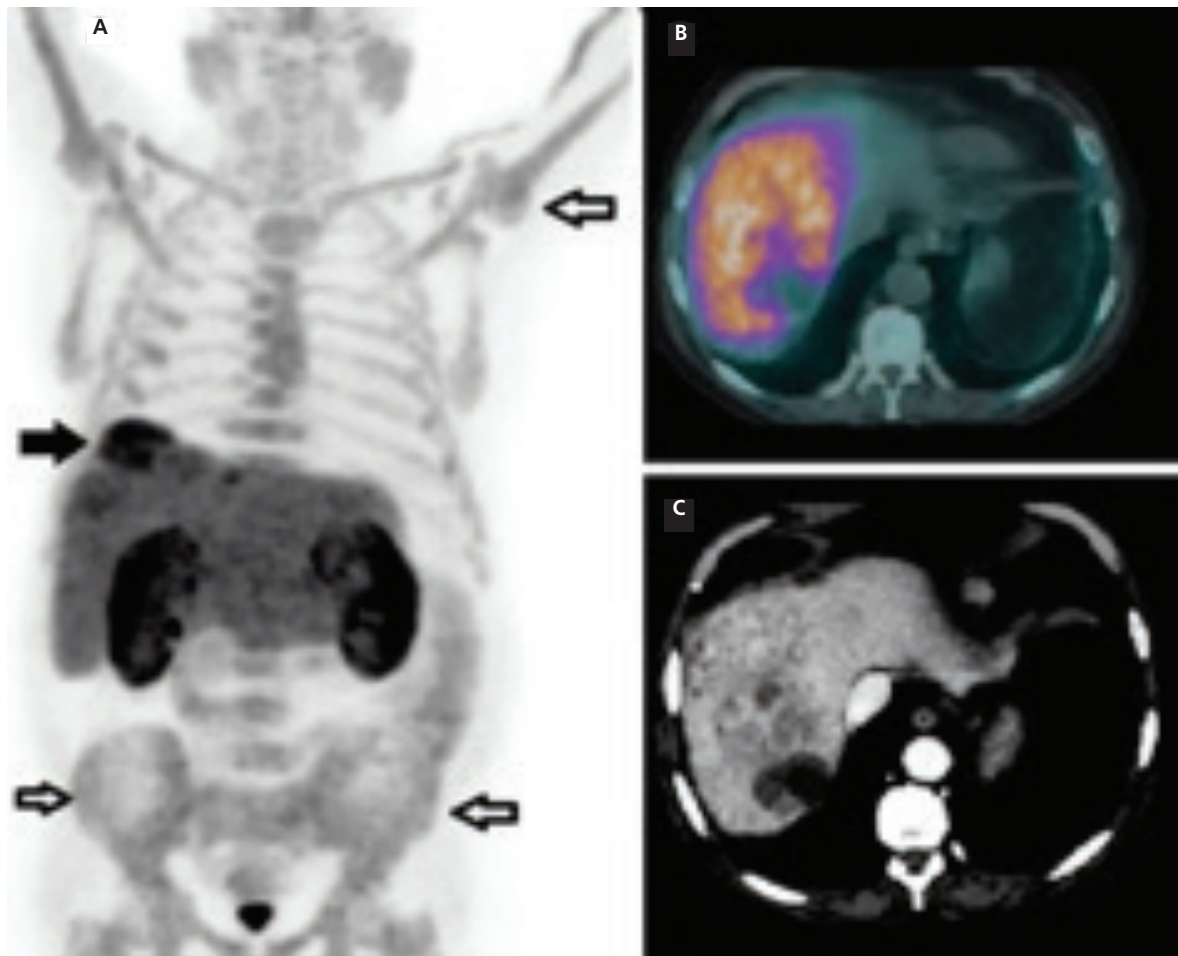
A 57-year-old man was diagnosed as having thalassemia intermedia at the age of 3 years (genotype CD39/IVS 1-6). He received sporadic blood transfusions since childhood and was submitted to splenectomy at the age of 15 years due to giant splenomegaly. Over the years, he developed hemochromatosis secondary to iron overload and was infected by hepatitis C, which was most probably transmitted via blood transfusion before 1990. In April 2018, during a periodical clinical follow-up, an abdominal ultrasound examination revealed multiple lesions in the right hepatic lobe, subsequently confirmed by contrast-enhanced/computed tomography (ce-CT). The patient underwent biopsy which resulted positive for well-differentiated hepatocellular carcinoma (HCC). He received sorafenib until September 2018 when treatment was discontinued due to the onset of cutaneous toxicity and evidence of progressive disease shown by ce-CT. He was enrolled for a loco-regional treatment of the hepatic lesion through radioembolization with ⁹⁰Y-microspheres. Before the radioembolization procedure, he was submitted to positron emission tomography/CT (PET/CT) with ¹⁸F-choline. (A) PET maximum intensity projection showed increased tracer uptake in the hepatic dome (black arrow) and diffuse hyperactivity in the axial and appendicular skeleton (black counter arrows). The corresponding fused PET/CT (B) and ce-CT (C) axial slices demonstrated multiple lesions, with a necrotic peripheral component, in the right hepatic lobe, characterized by intense ¹⁸F-choline incorporation with much higher uptake values (SUV_{max} : 17.0, SUV_{mean} : 6.1) than those calculated in the normal liver parenchyma (SUV_{max} : 7.7, SUV_{mean} : 5.7).
